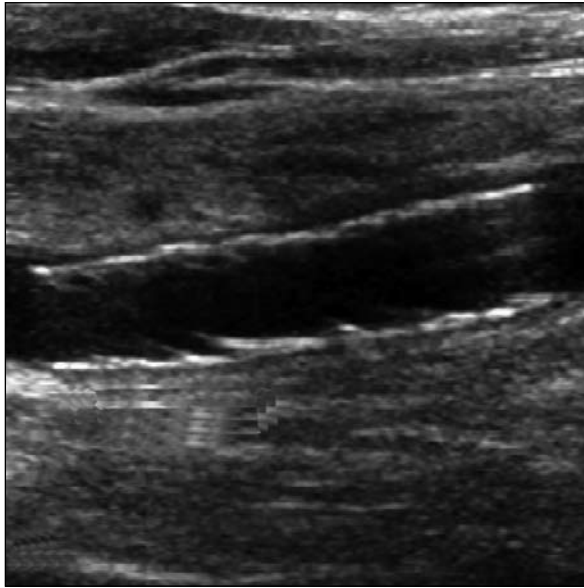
A colour Doppler scan of the right common carotid shows a patent stent with no evidence of any pseudoaneurysm or arteriovenous fistula
